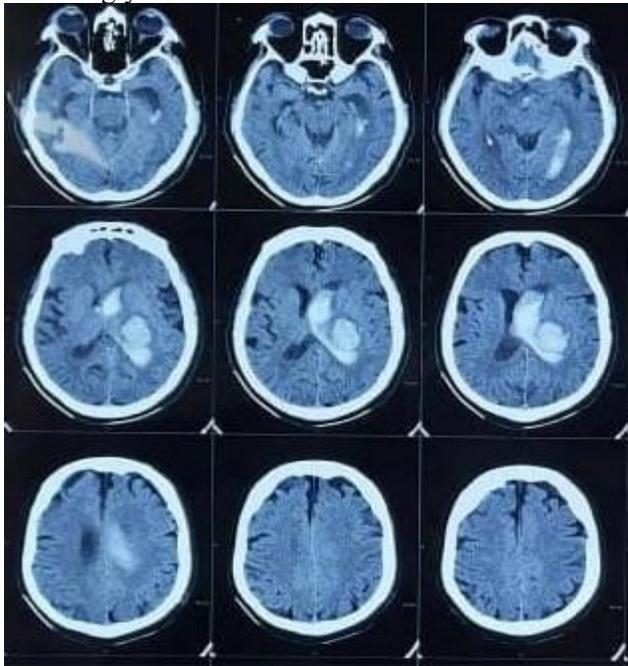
Findings of Haemorrhagic stroke in CT scan (without contrast) of a 27 years old male suffering from Indian red scorpion sting
